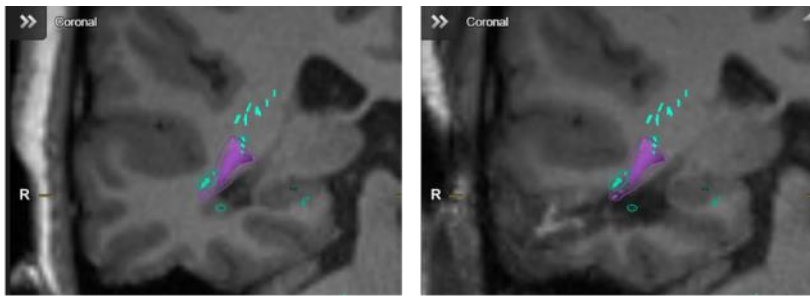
patient with a focal cortical dysplasia that showed a postoperative superior quadrantanopia. Pre- (left) and postoperative (right) coronal MRI, with projections of TMS-OR (green) and anatomy-based OR (purple).
